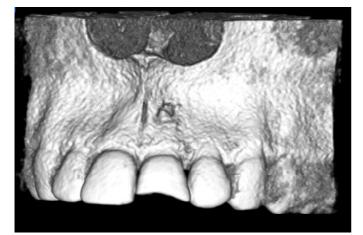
6: CBCT 3D view-denudation of buccal cortical plate seen with 21
